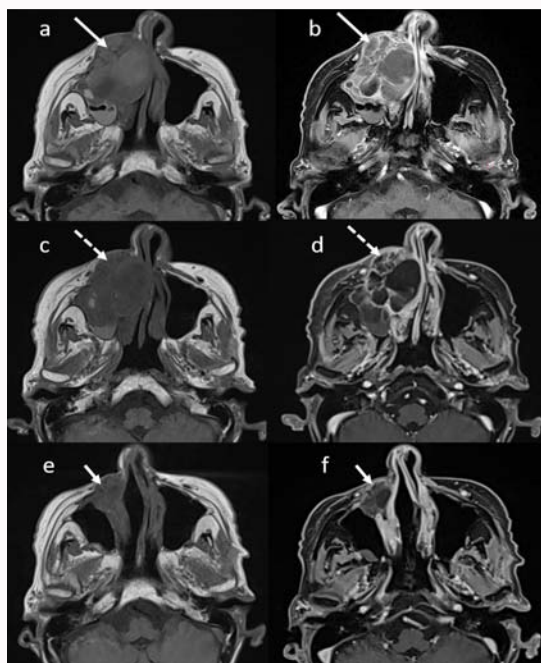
a) and b): Baseline MRI of 28 FEB 2023 that documented the progression of disease; c) and d) MRI of 04 Jul 2023, performed after Radiotherapy, that showed stable disease; e) and f) MRI of 30 Nov 2023 demonstrating major partial response (near complete remission).
